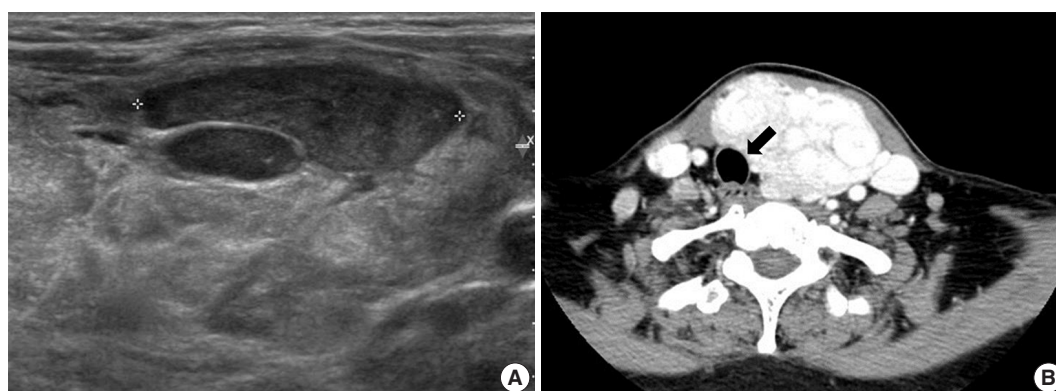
Radiologic and core needle biopsy images of the thyroid. (A) Thyroid ultrasound image showing multiple hypoechoic solid nodules with well-defined margins. (B) Thyroid computed tomography revealing multinodular masses in the left thyroid lobe displacing the laryngotracheal airway (arrow).
